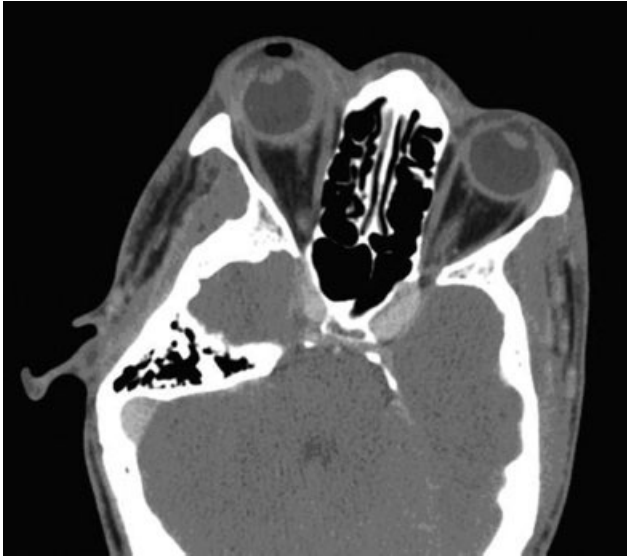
CT of the orbit with contrast showing right preseptal and periorbital soft-tissue swelling with fluid collection.
